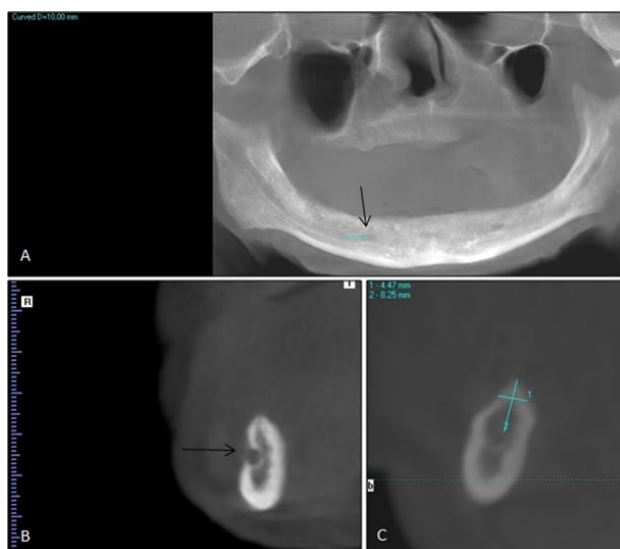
10 mm distal of right mental foramen on panoramic reconstruction view of cone beam computed tomography (A). Marked right mental foramen on coronal section image (B). Measurement of alveolar crest dimensions on coronal section image (C). (mental foramens were marked with black arrows)
